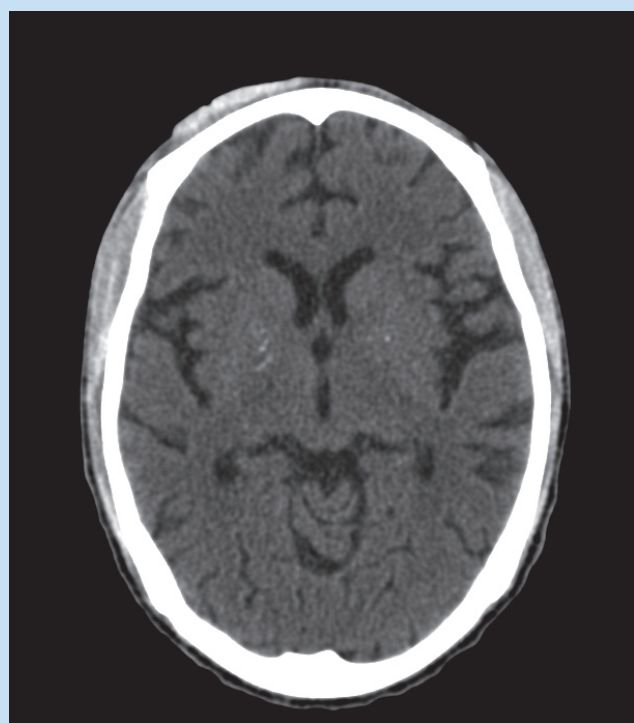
Non-contrast CT scan brain of a 28-year-old RVD-positive male patient showing significant atrophy and basal ganglia calcification.
